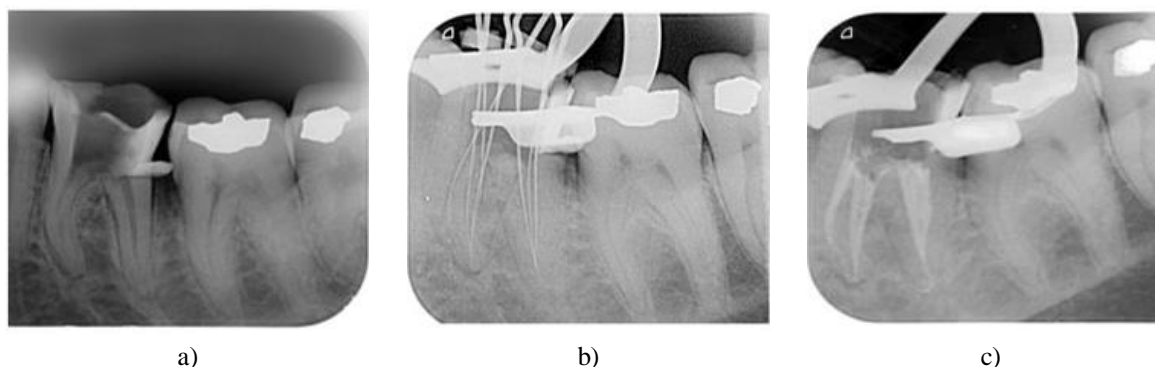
a) preoperative radiograph, b) working length radiograph, and c) post obturation.
